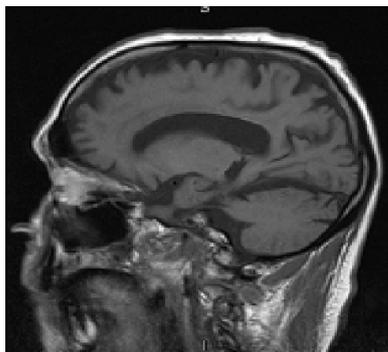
Brain MRI showed mild volume loss and microangiopathy, but no stroke, mass lesions or any other abnormalities.
